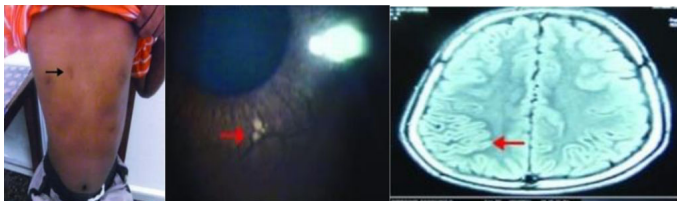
a) Neurofibromas on the body of affected child b) lich nodules in eyes c) CT-Scan
